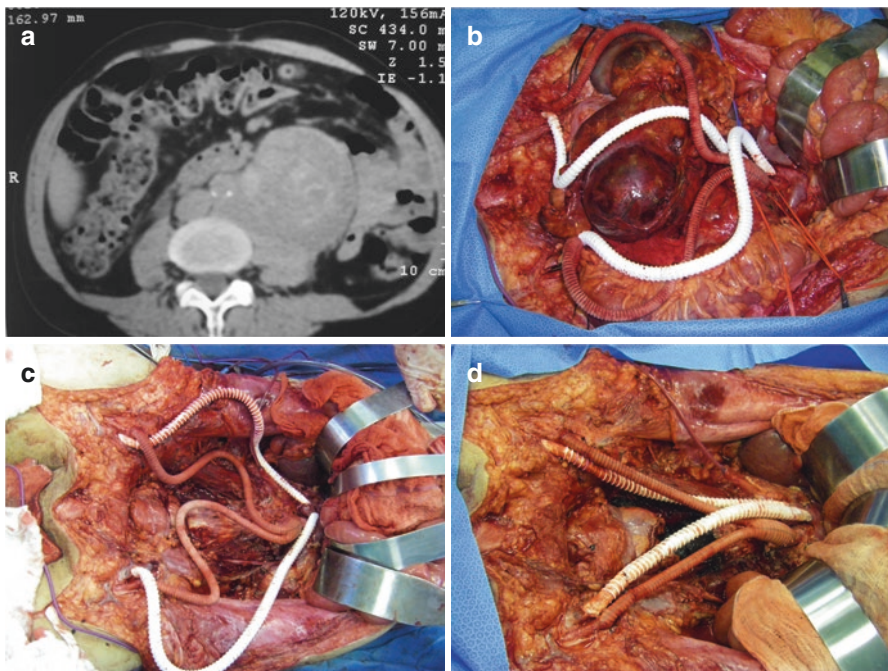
Temporary aorto-bifemoral and bifemoral vein to inferior vena cava derivation for treatment of a germ cell tumor invading the infra-renal aorta: (a) CT scan of the tumor showing aortic invasion. (b) Temporary aorto-bifemoral (Dacron) and bifemoral vein to inferior vena cava (ringed PTFE) grafts prior to tumor resection. (c) Redundant grafts after tumor resection. (d) Final appearance after graft adjustments
